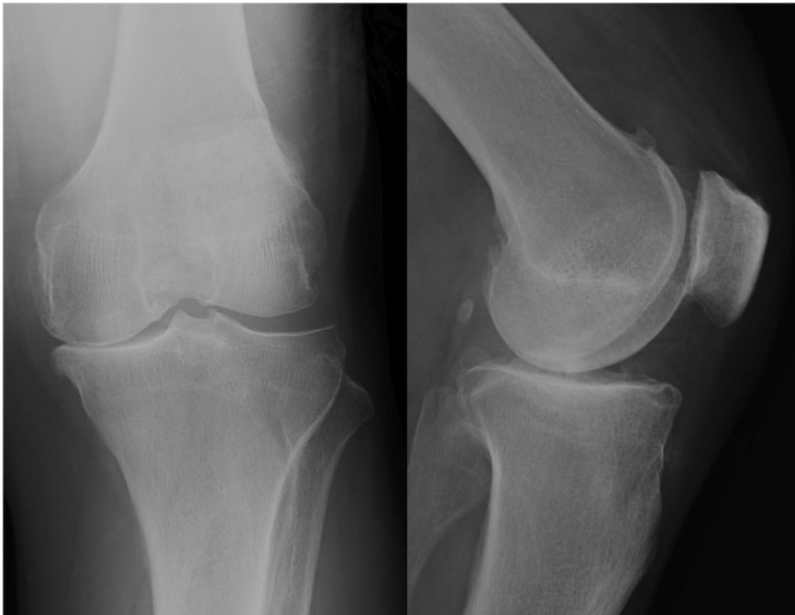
Anteroposterior and lateral radiographs in Case 1 show loss of the medial tibiofemoral joint space and stage IV osteoarthritis (Kellgren–Lawrence classification).
